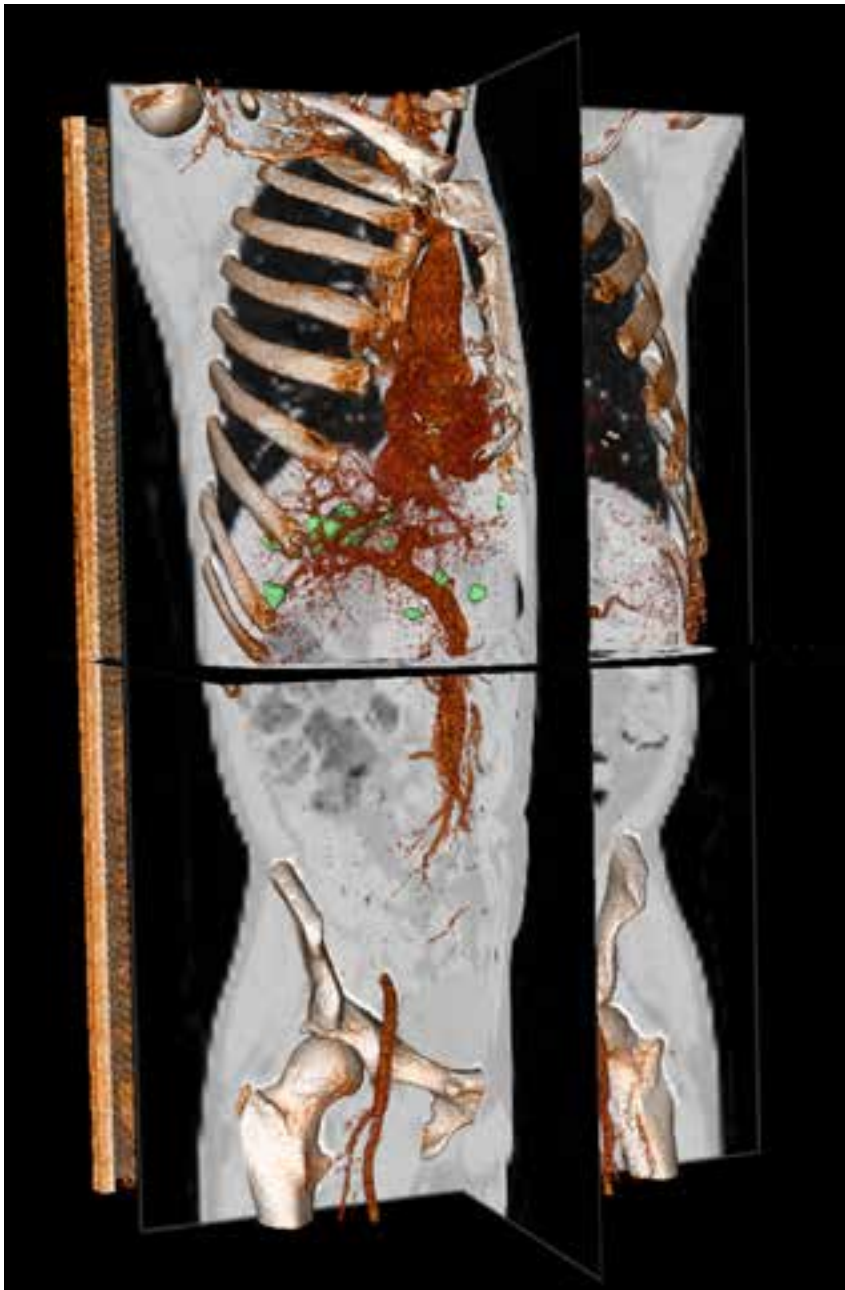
Liver lesion segmentations (green) in a CT abdomen examination.
